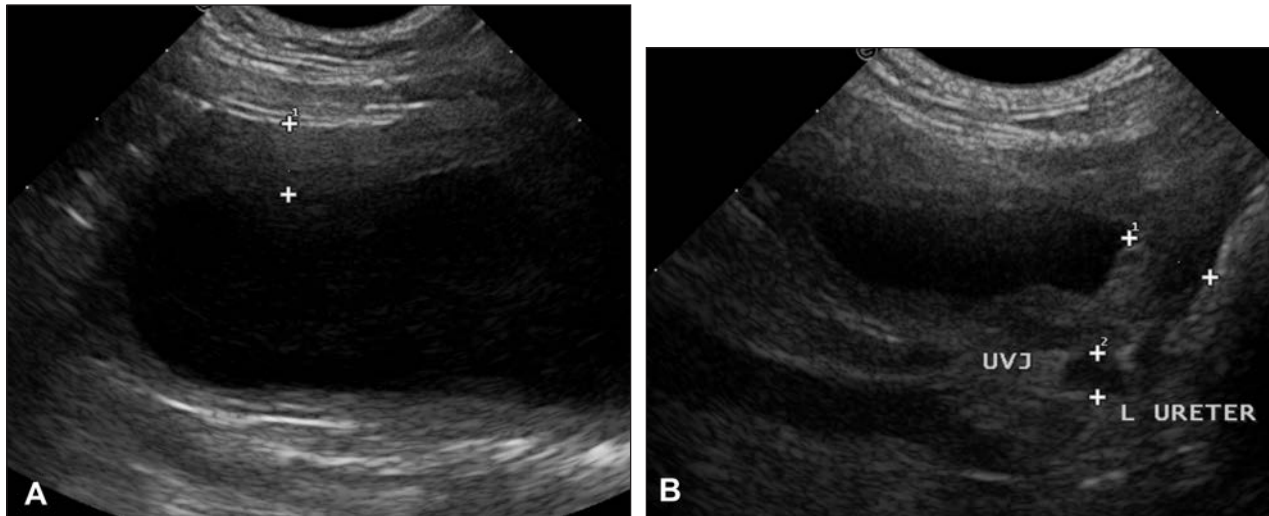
Longitudinal (A) and transverse (B) ultrasonographic images of the urinary bladder of a 13-year-old castrated male Dalmatian evaluated because of blood dripping from its prepuce after urination. Images were obtained transabdominally with an 8-MHz convex transducer at a depth of 5 cm. L = Left. UVJ = Ureterovesicular junction.
